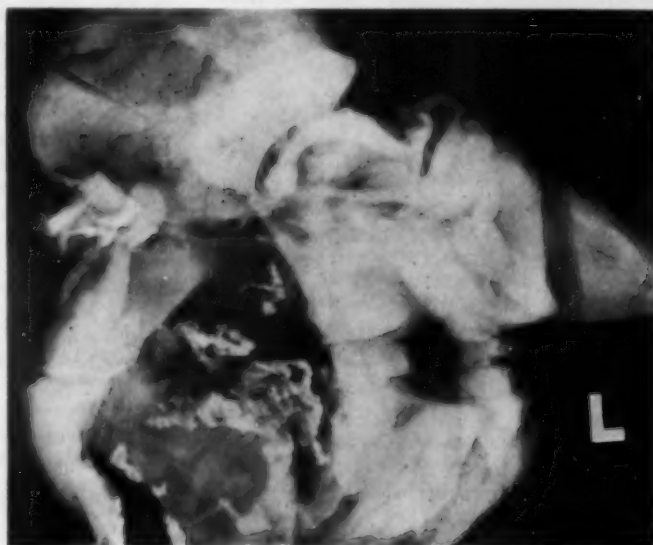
An x-ray of the same view as that in Figure 2A, after blocks were removed for sections. The extent of the calcification can be easily appreciated throughout the interventricular septum.
